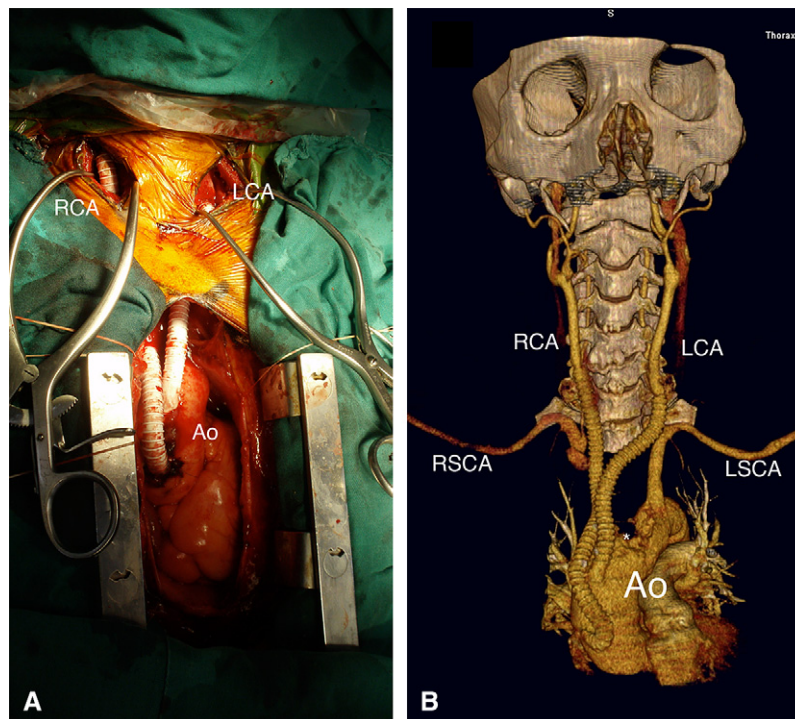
A, Intraoperative photos: ascending-aorta–bilateral carotid artery bypass graft. Ao, Ascending aorta; LCA, left common carotid artery; RCA, right common carotid artery. B, Reconstruction of the computed tomogram indicates the arch branches, bypass graft, and intra-aortic lesion. Ao, Ascending aorta; LCA, left common carotid artery; LSCA, left subclavian artery; RCA, right common carotid artery; RSCA, right subclavian artery. Asterisk, Intra-aortic lesion.
